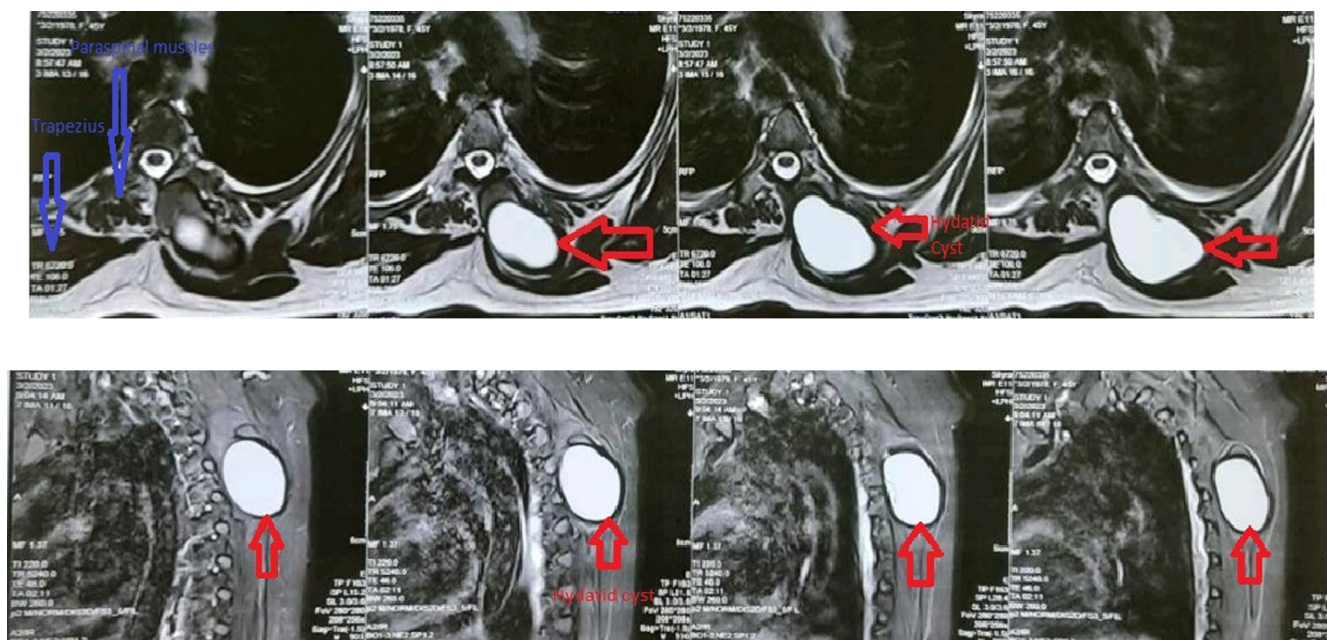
T2 weighted MRI, transverse section showing trapezius and paraspinal muscles of the right side (blue labeled), and hyperintense unilocular hydatid cyst in the area of left paraspinal muscles (red labeled). Longitudinal section showing hyperintense unilocular hydatid cyst surrounded by a hypointense rim.
